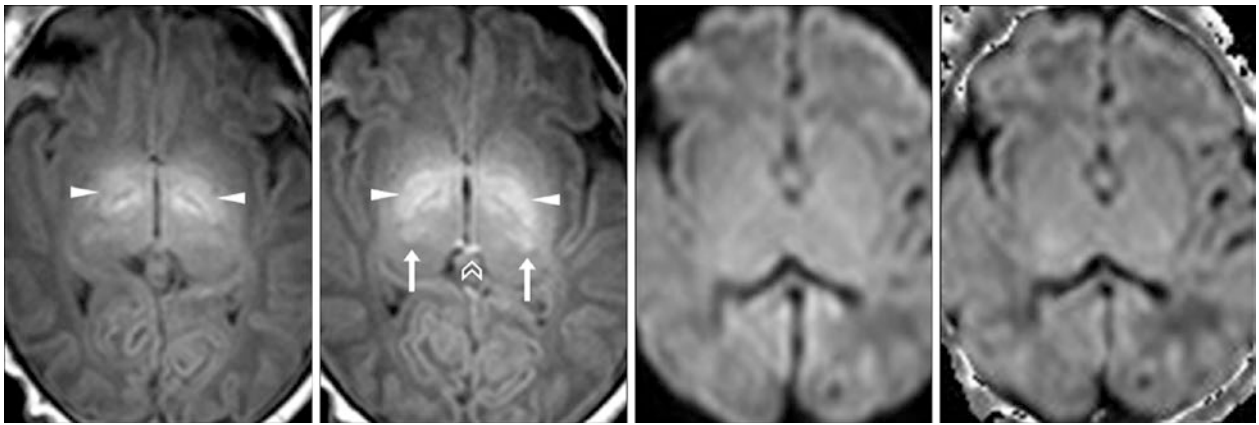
A 7-day-old term neonate with a seizure at birth and respiratory depression had a normal 3T MRI that included GE T1WI (*left* and *left middle*), DWI (*right middle*) and an exponential DWI that removes vasogenic edema (*right*) both showed no basal ganglial
